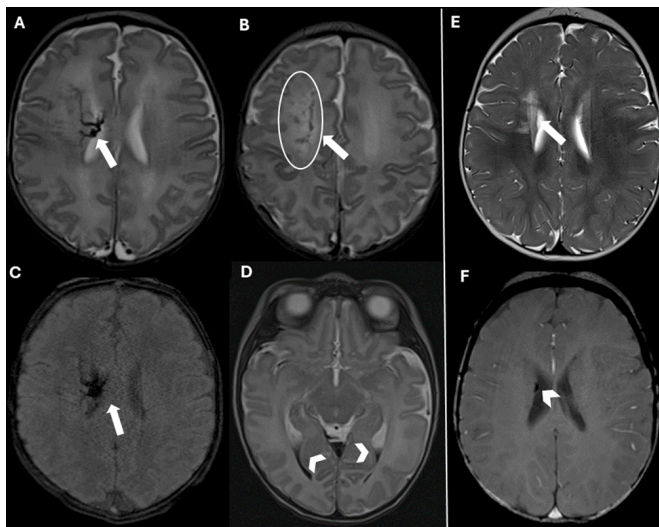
A. B. D. Axial T2 Weighted Images, C. Susceptibility Weighted Imaging (SWI) showing right thrombosis of the medullary veins (arrows in A, B, C) with associated slight loco regional white matter oedema (B, circle) and haemorrhage (D, arrowheads). E. Axial T2 Weighted Images and F. Axial Susceptibility Weighted Imaging (SWI) follow-up MRI at 1 year of life showing gliotic evolution of the periventricular white
